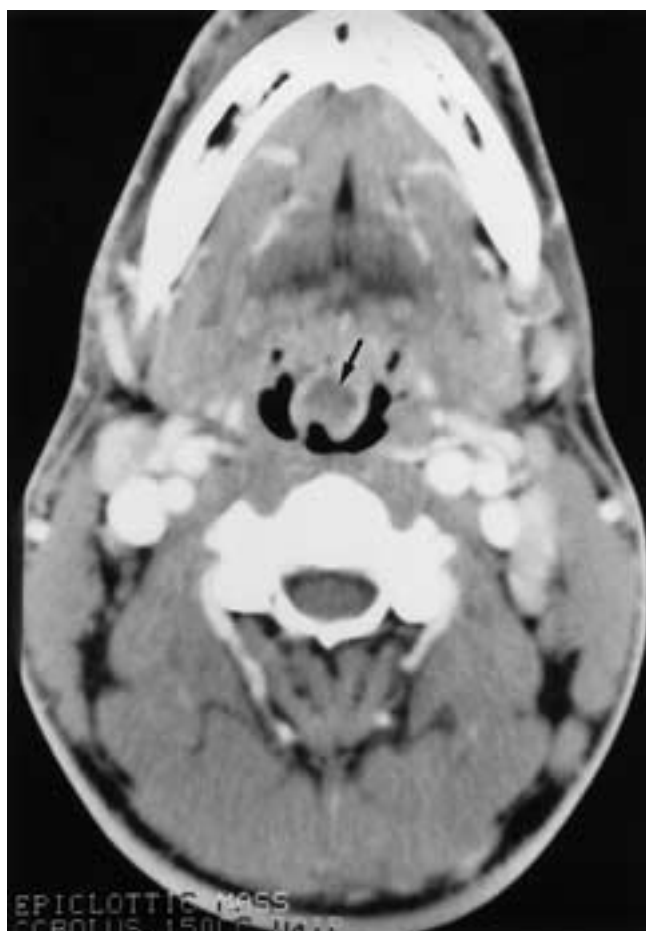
Epiglottic abscess in an adolescent with severe sore throat. Axial contrast-enhanced CT shows a mass in the epiglottis (arrow), with partial airway obstruction. At surgery this was found to be an epiglottic abscess.
